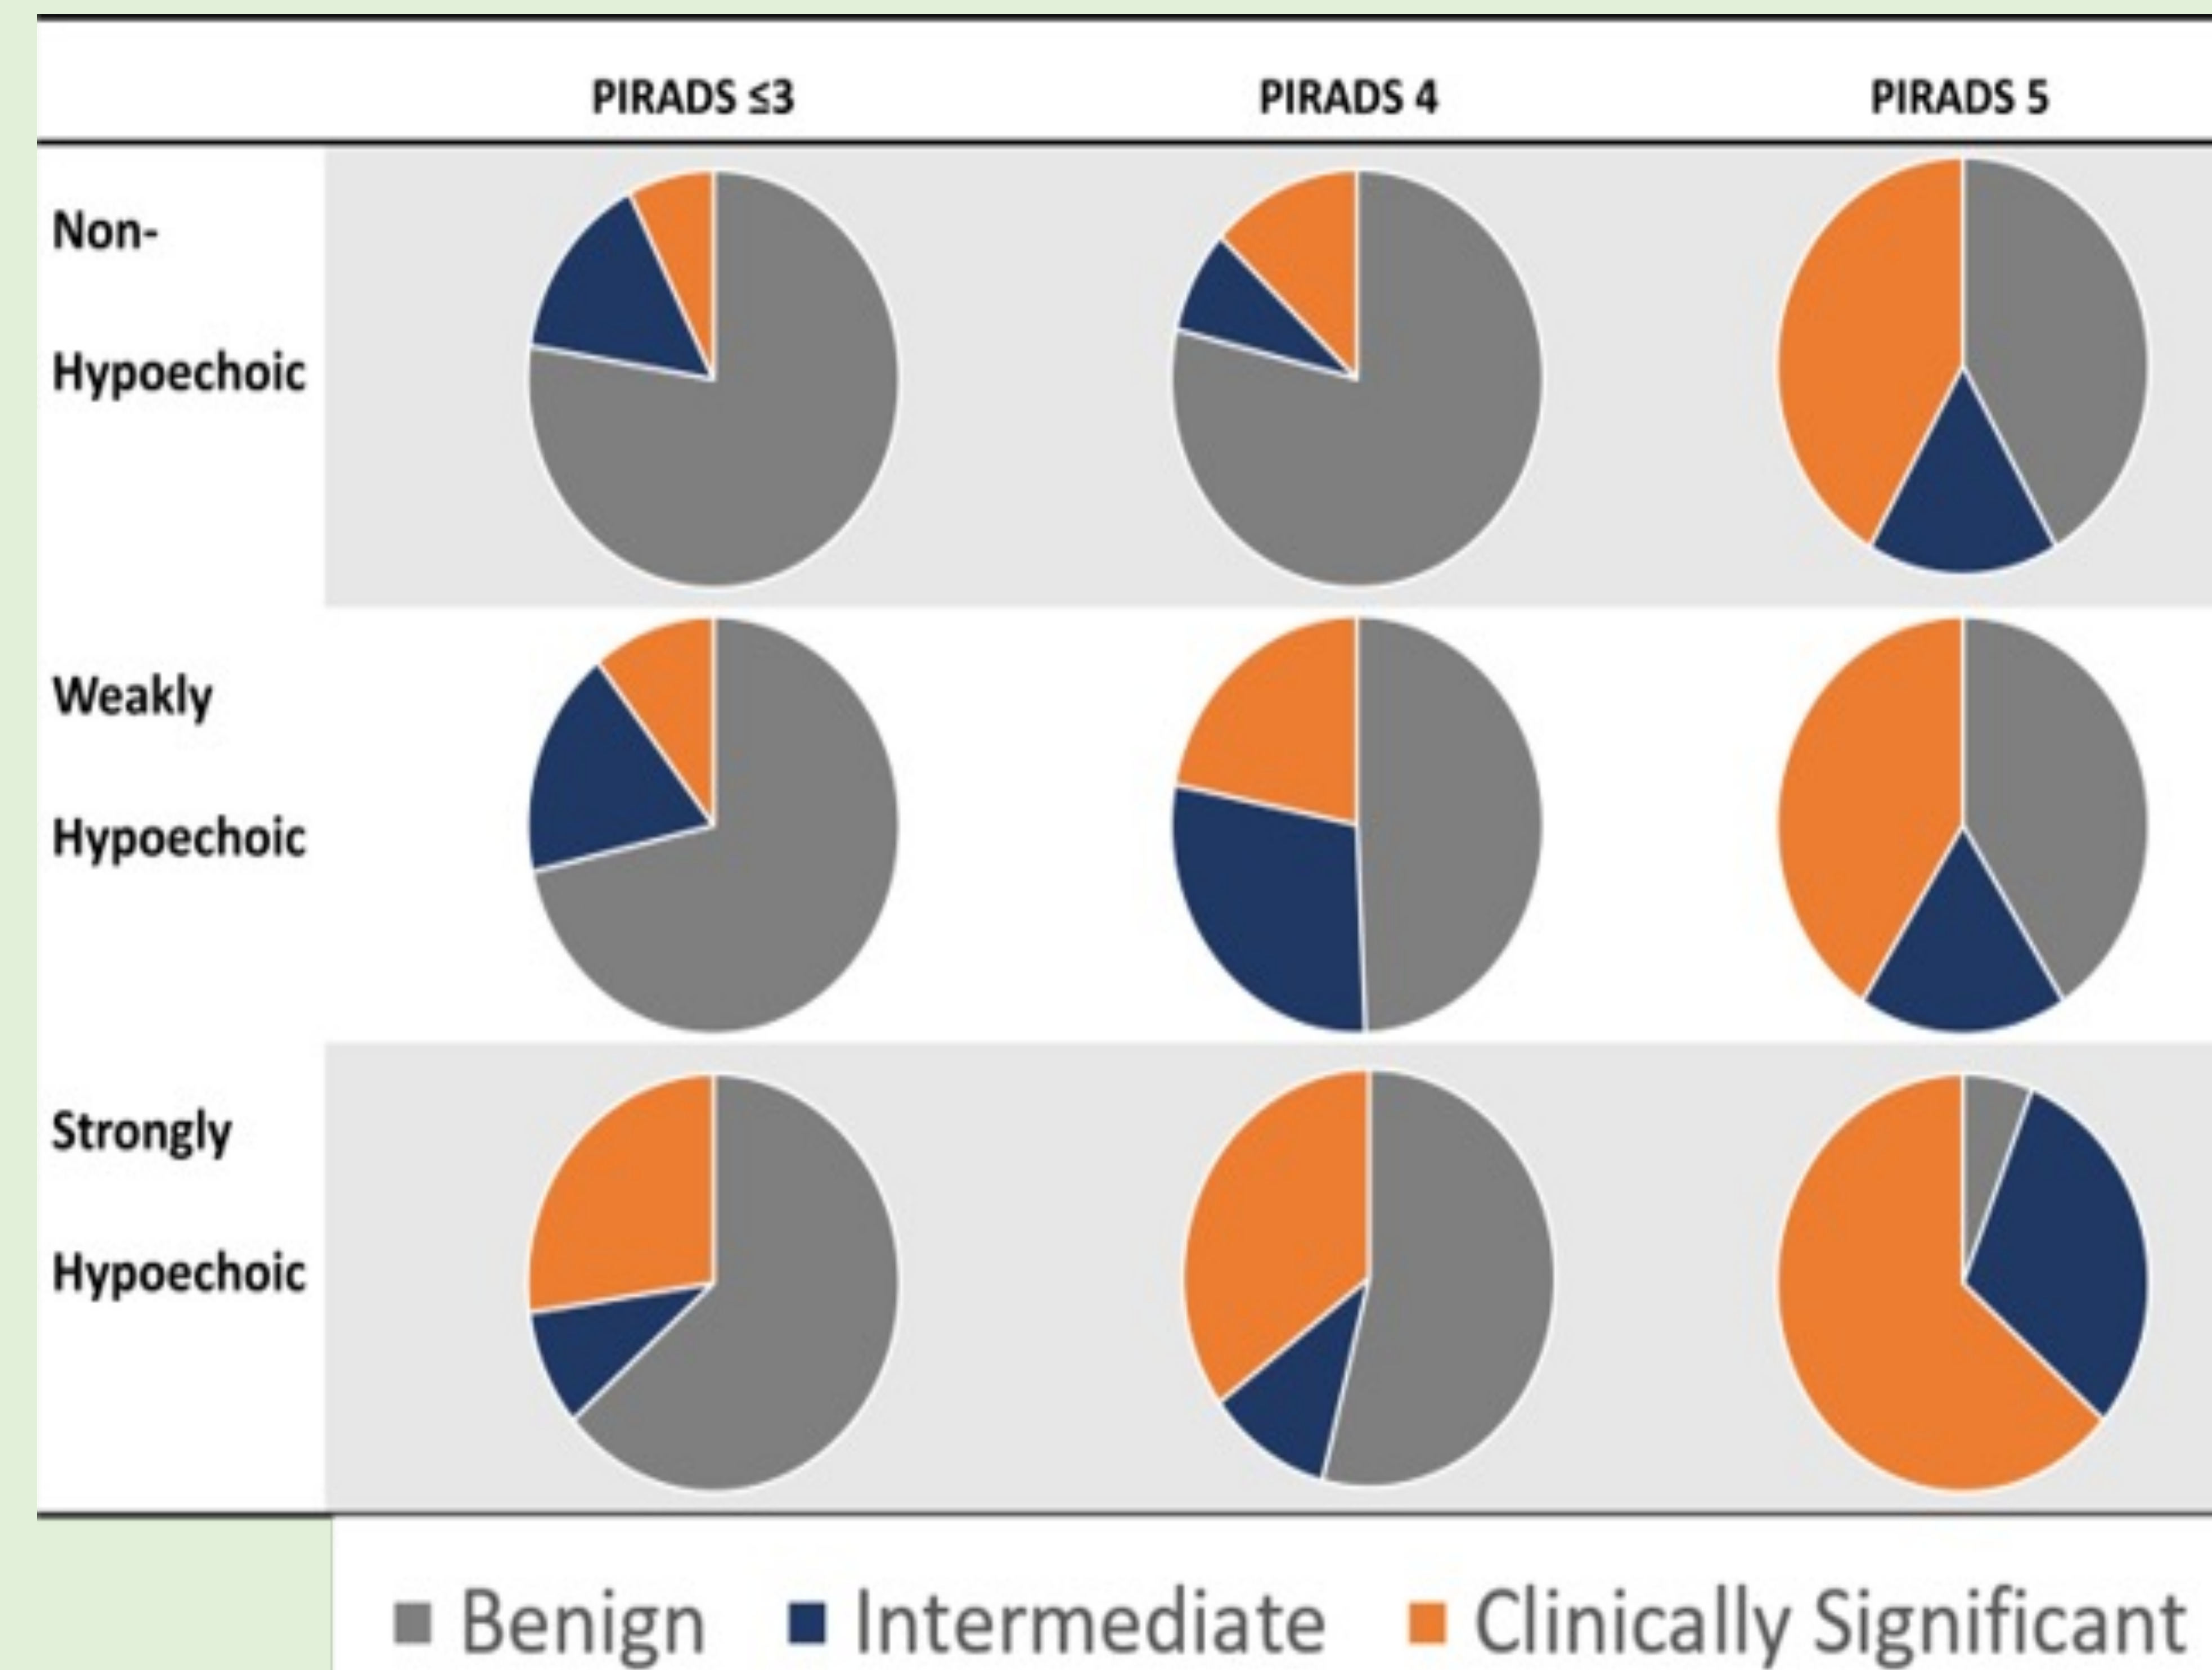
Distribution of Clinically significant (Gleason Grade  $\geq 7$ ), Intermediate (Gleason Grade = 6), and Benign lesions of prostate cancer detected by MP MRI/US guided Biopsy
